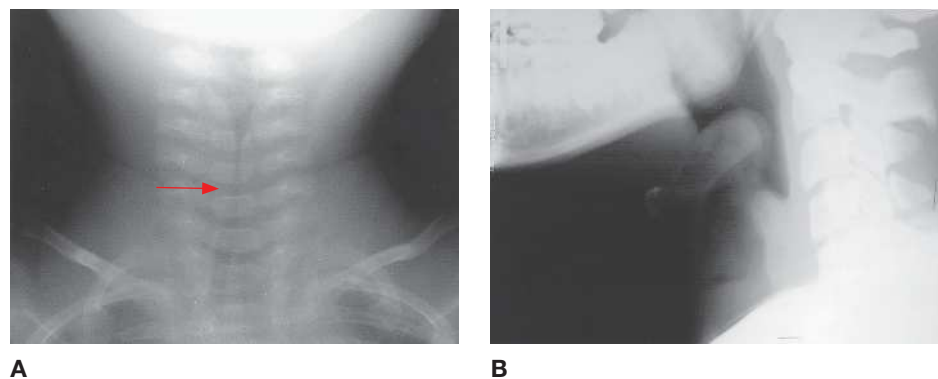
Croup vs epiglottitis. (A) Croup. X-ray shows marked subglottic narrowing of the airway (arrow). (B) Epiglottitis. The classic swollen epiglottis (“thumbprint sign”) and obstructed airway are seen. (Reproduced with permission from Stone CK, Humphries RL. *Current Diagnosis & Treatment: Emergency Medicine*, 7th ed. New York: McGraw-Hill, 2011, Fig. 32-10A and 50-4.)
